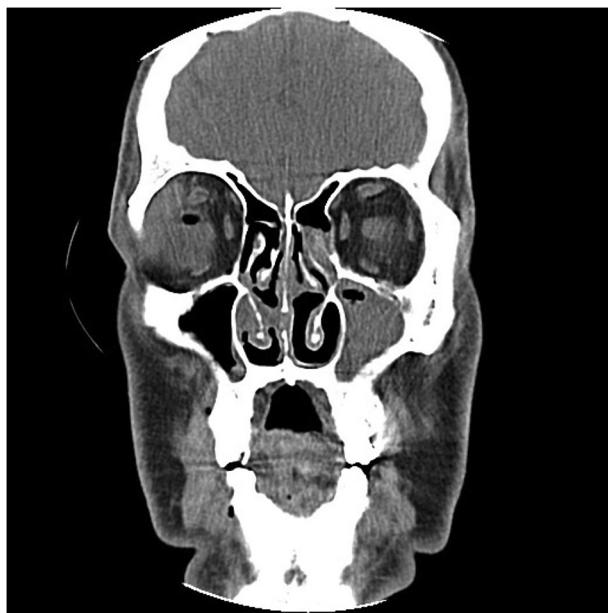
Paranasal sinus computed tomography (CT) scan shows right maxillary sinusitis.
